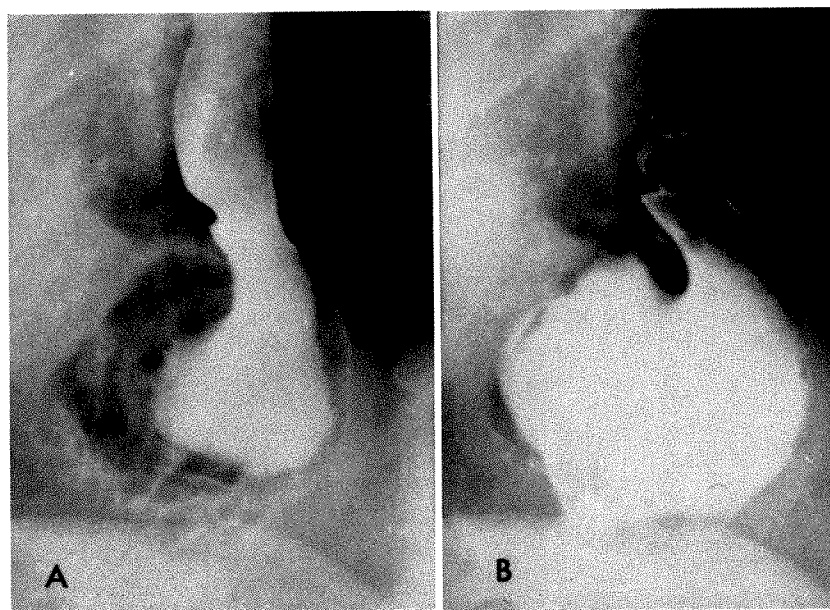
(A) Roentgenogram shows barium bolus beginning to enter the hernia, whereas B made 2 or 3 seconds later shows the entire bolus obviously within the hernia, thus proving that the esophagogastric junction lies *above* the diaphragm; *i.e.*, the hernia is of the sliding type.
